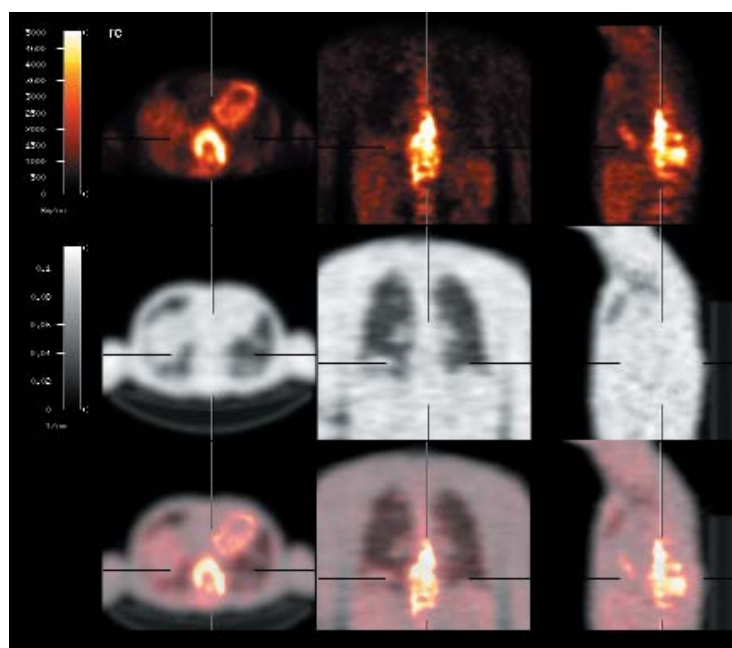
Fluorine-18 fluorodeoxyglucose PET (FDG PET) shows marked excess enrichment over several segments (circa thoracic vertebral bodies 9 to 12), with a standard uptake value (SUV max) of 9.1.
